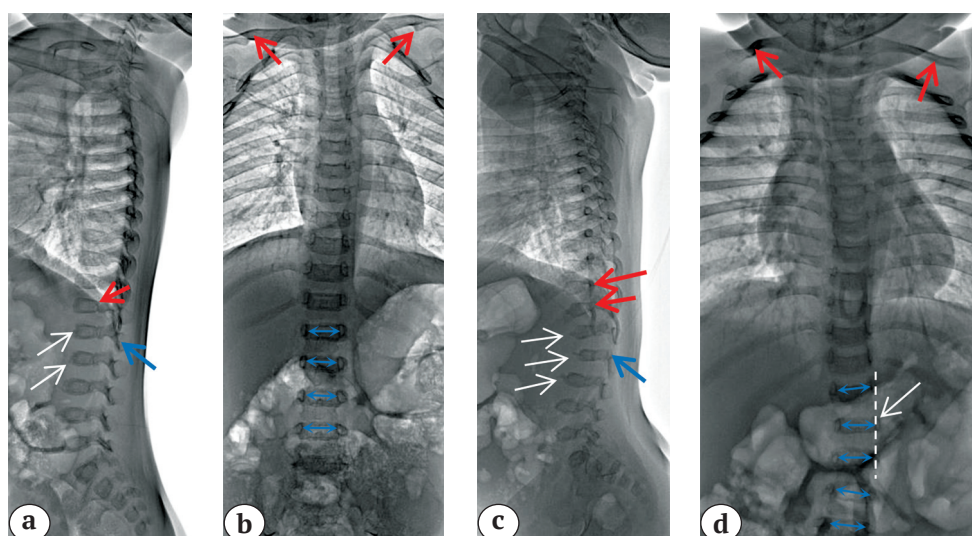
X-rays of the spine and chest of the patients 1 (a, b) and 2 (c, d): posterior wedging of lower thoracic vertebrae (a, c – red arrows); anterior wedging of upper lumbar vertebrae (a, c – white arrows); lumbar kyphosis (a, c – blue arrows); curved and high-positioned clavicles (b, d – red arrows); the absence of an increase in the interpedicular distance in the lumbar spine (b, d – blue arrows); laterolisthesis L2 (d – white arrow).
